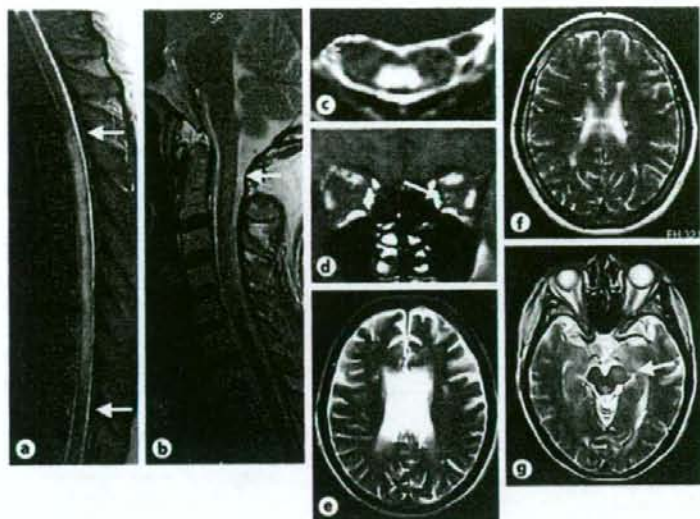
Representative MR images of anti-AQP4 antibody-positive and antibody-negative patients with OSMS. a Spinal cord T₂-weighted MRI of a 60-year-old patient with anti-AQP4 antibody, showing longitudinal lesions of high signal intensity extending over several segments at relapse. b Spinal cord MRI of a 49-year-old female patient who has no anti-AQP4 antibody, showing longitudinal lesions of high signal intensity but less than 3 vertebral segments at relapse. c T₂-weighted axial image of a 52-year-old patient with anti-AQP4 antibody, showing syrinx formation mainly located in the center of the spinal cord as signal hyperintensity with a
